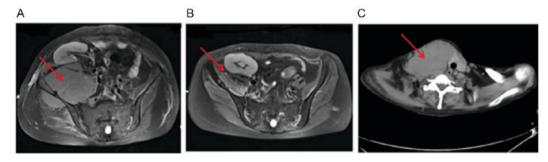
Extramedullary plasmacytomas prior to and following autologous peripheral stem cell transplantation. (A) MRI (fat suppression T2WI) identified an increase in the right internal iliac muscle mass, prior to transplantation (25 May 2015). (B) MRI (fat suppression T2WI) demonstrated a decrease in the right internal iliac muscle mass, 2 months post-transplantation (24 July 2015). (C) Computed tomography scan revealed a large lump located in the right neck which moved the trachea towards the left (21 October 2015). MRI, magnetic resonance imaging; T2WI, T2-weighted image. The arrow in each of the images point to the plasmacytoma.
